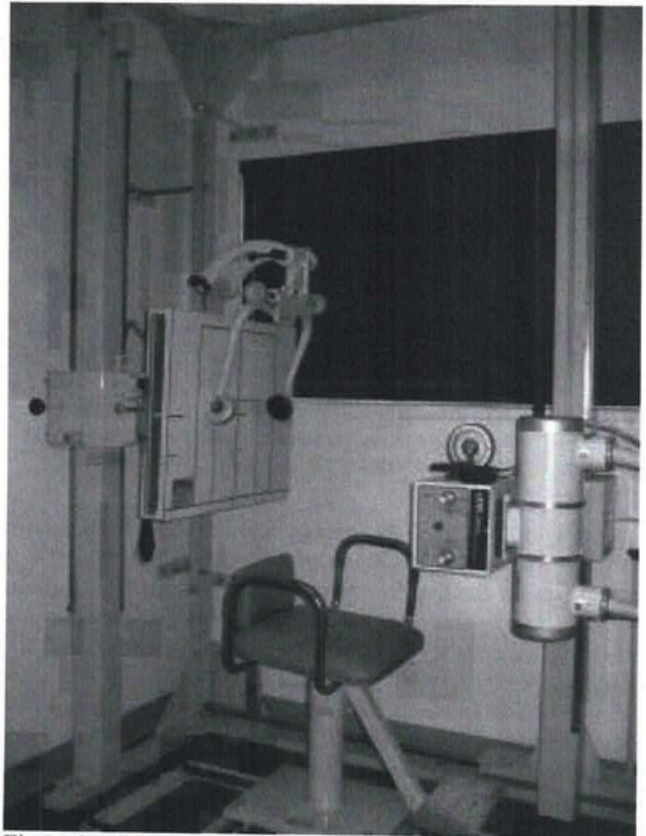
Upper cervical x-ray configuration that includes a laser-aligned frame, a laser mounted to the x-ray tube, positioning chair, and head clamps for accuracy in measuring upper cervical subluxation.
